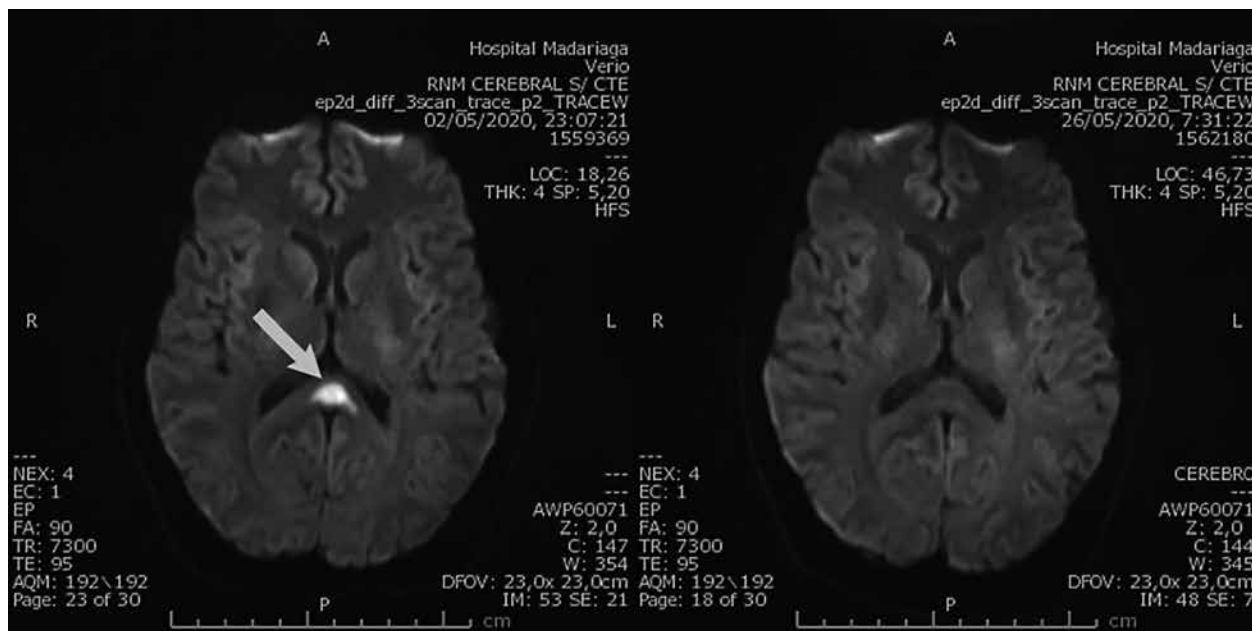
Central Nervous System MRI with gadolinium showing lesion in the central splenium of the corpus callosum in the diffusion-weighted imaging (image on the right). After two weeks the lesion in the corpus callosum disappeared (image on the left).
